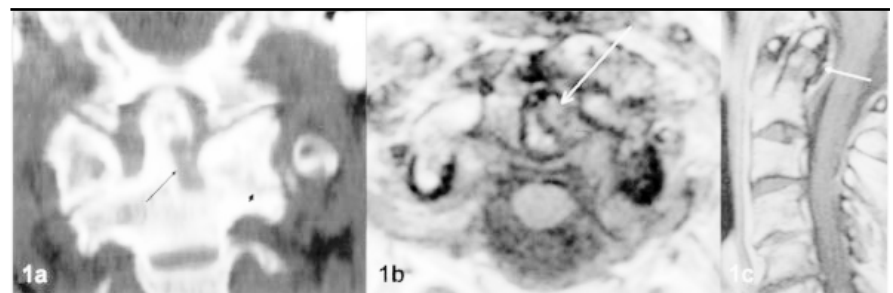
CT (a) disclosed a punched-out lesion (long thin arrow) of the dens of C2 with an overhanging edge of the cortex at the base of it, surrounded by a thin sclerotic wall. There was osteoarthritis (small thick arrow) in the left atlanto-axial joint. MRI (b, c) disclosed a periodontoid soft-tissue mass (arrows) with an associated sharply delineated erosion of the dens with tophus characteristics.
